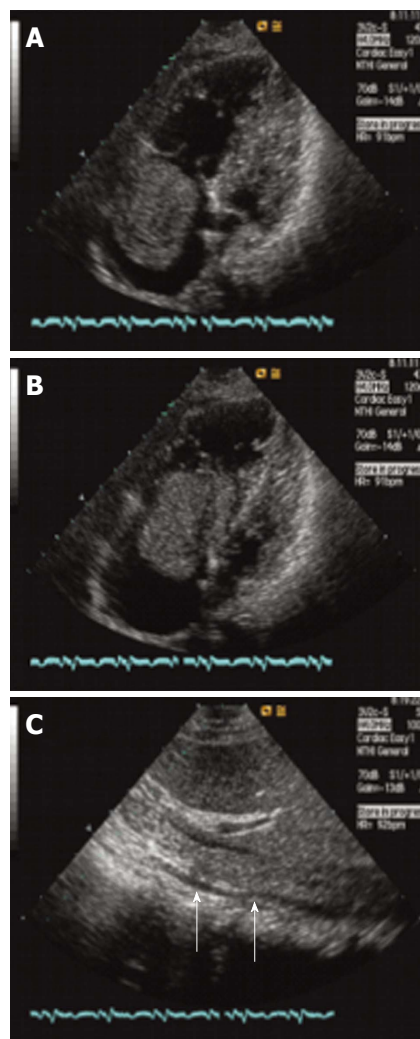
Echocardiogram of the heart and inferior vena cava. A, B: Axial image demonstrates a mass within the right atrium that moves back and forth through the tricuspid orifice into the right ventricle in the systolic and diastolic period; C: Axial image demonstrates a mass within the inferior vena cava (arrows).
